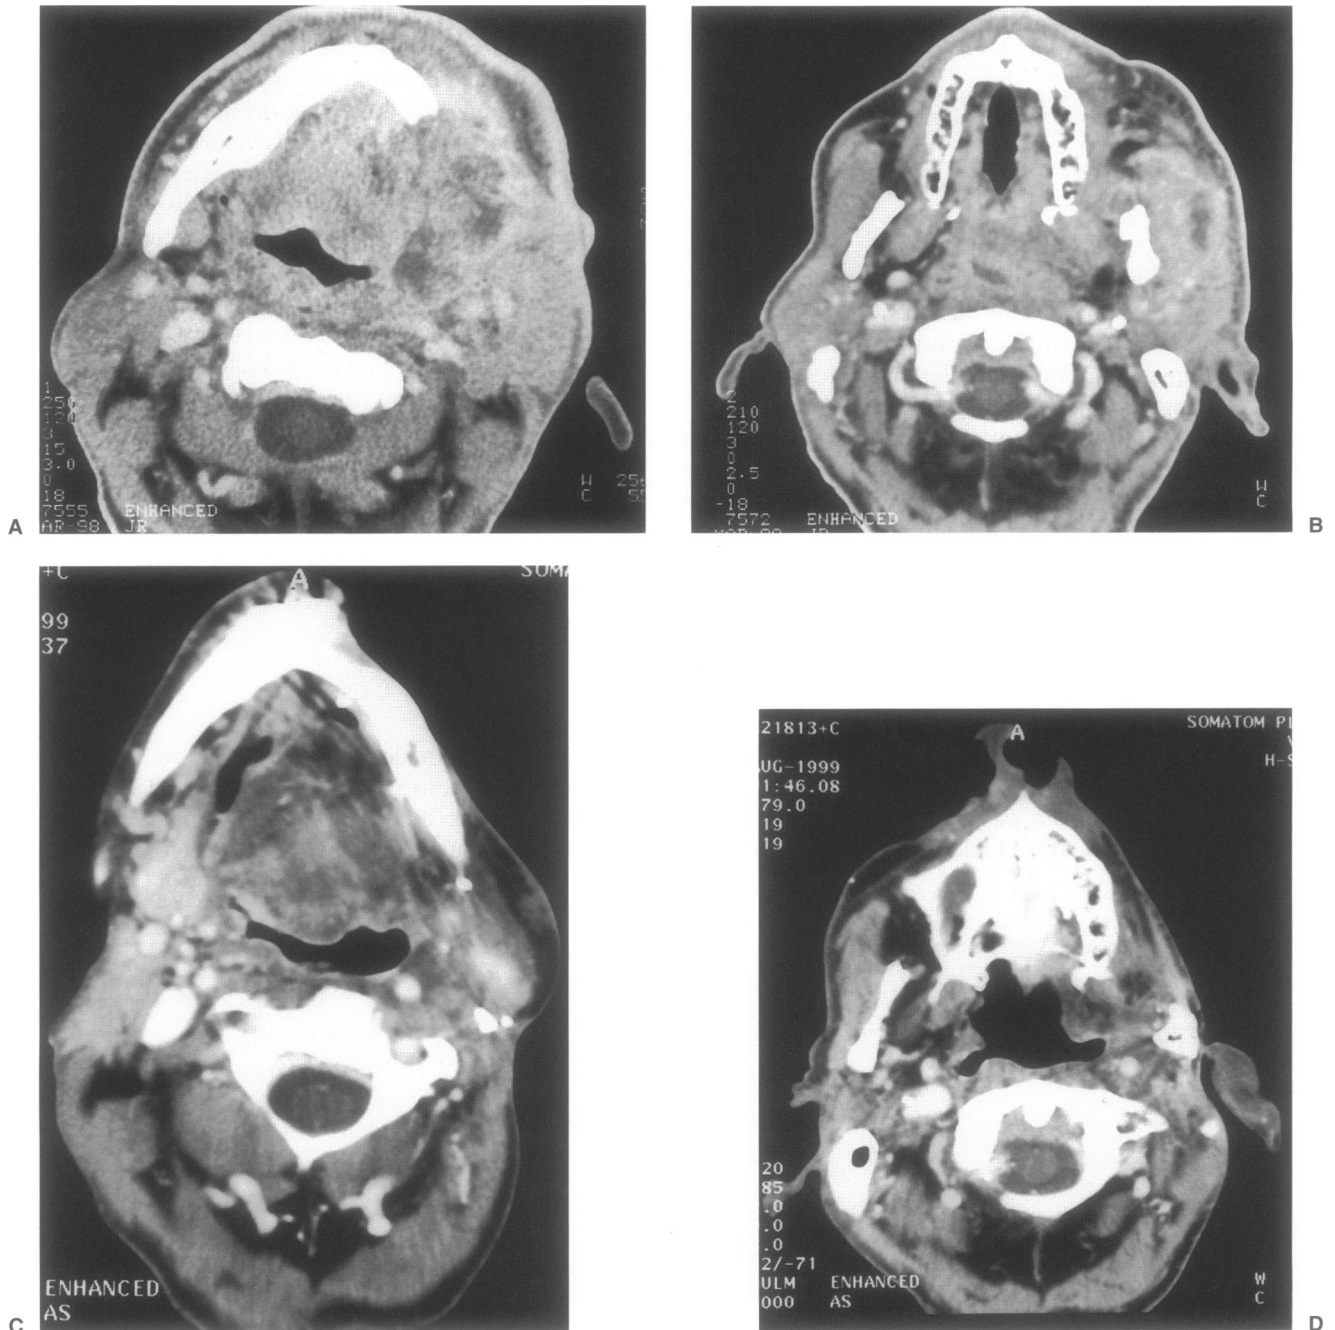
Preoperative CT scan of the mandible (A) and pterygoid region (B). Postoperative CT scan (C,D) after left hemimandibulectomy, resection of cheek, partial glossectomy, left radical neck dissection, infratemporal fossa resection of medial pterygoid masseter, and temporalis muscle with fibular free flap and pectoralis myocutaneous flap reconstruction.
